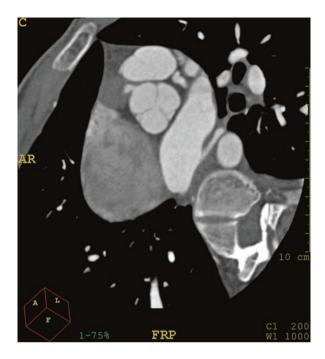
Image obtained from a patient with an acute myocardial infarction caused by thrombosis of a right coronary artery Kawasaki aneurysm (*arrow*). Kawasaki disease results from a mucocutaneous viral infection acquired during childhood. Typically, multiple aneurysms may develop in the coronaries and in other systemic vessels. Thrombosis of these aneurysms may occur later in life. [Garcia MJ. Intracardiac, myocardial and extracardiac abnormalities. In: Budoff MJ, Achenbach S, Narula J, editors. Atlas of cardiovascular computed tomography. Philadelphia: Current Medicine; 2007] *Caption from original*
